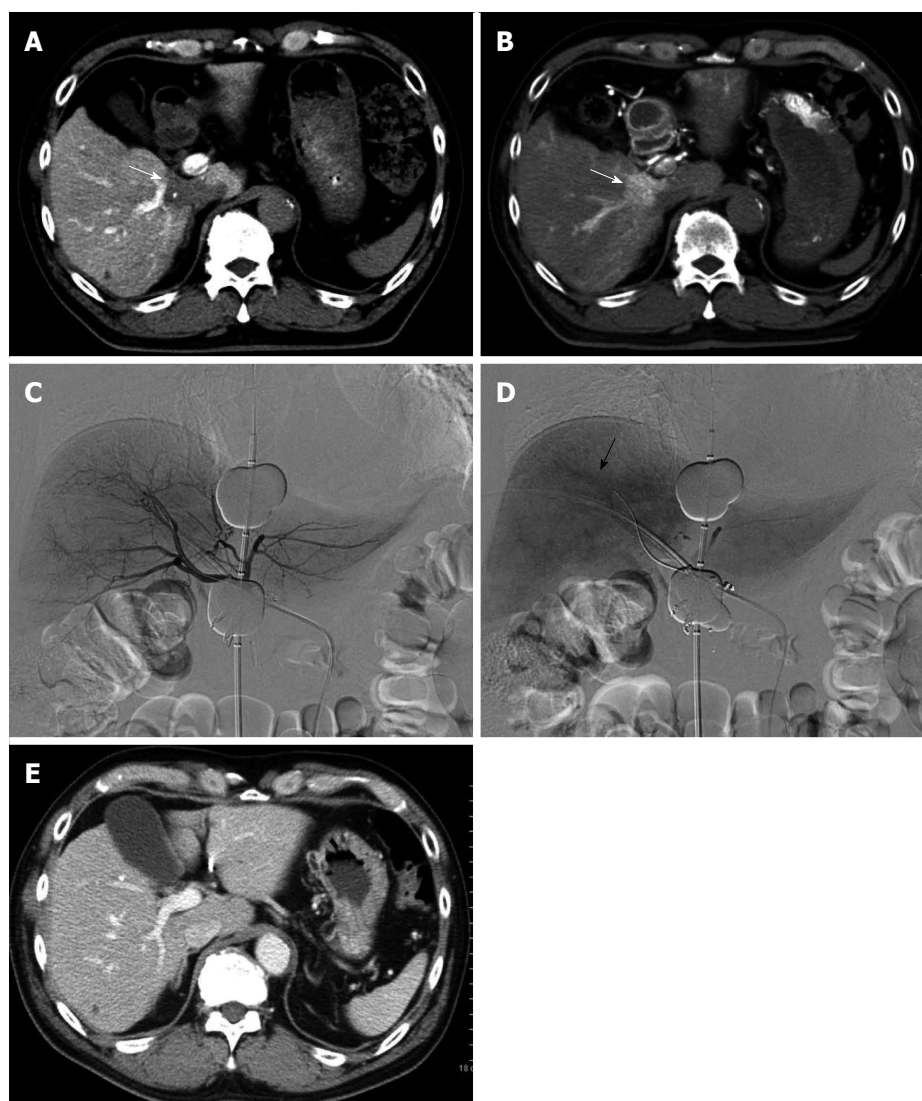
Retrograde-outflow percutaneous isolated hepatic perfusion for multiple hepatocellular carcinomas in a 64-year-old man. A patients received 2 sessions of transcatheter arterial chemoembolization for multiple hepatocellular carcinomas (HCCs) at other hospital. Computed tomography (CT) during arterial portography (A) and hepatic arteriography (B) demonstrated multiple HCCs with portal vein invasion (arrows). Retrograde-outflow percutaneous isolated hepatic perfusion (C, arterial phase; D, venous phase) was performed twice (arrow of D indicated a portal branch), and enhanced CT imaging 6 mo after therapy (E) revealed that the HCC was diminished.
